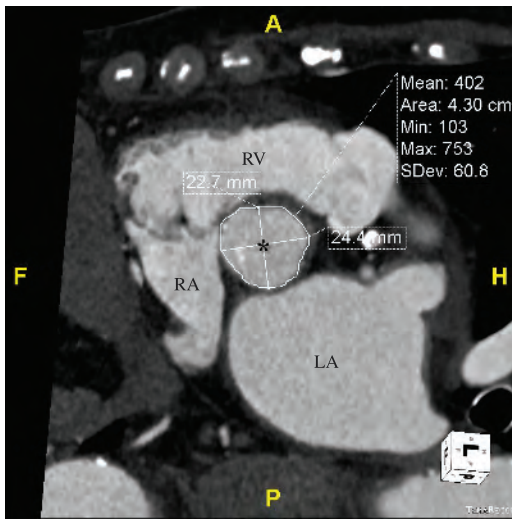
Computed tomography assessment of basal aortic annulus. Area, 4.3 cm²; diameter 22.7 mm × 24.4 mm. LA, left atrium; RA, right atrium; RV, right ventricle.
